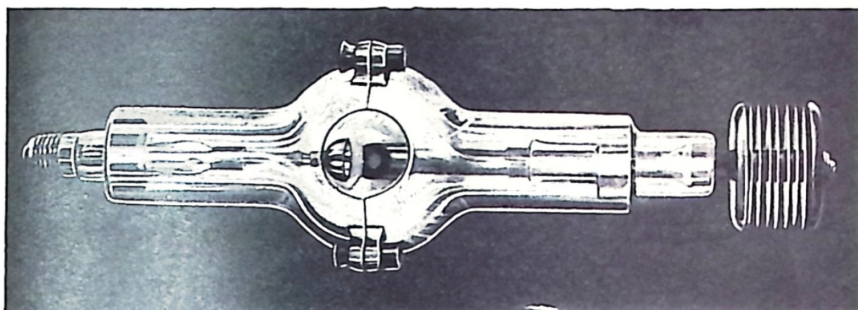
Radiator Type Coolidge X-Ray Tube Enclosed in Lead Glass Protective Shield
